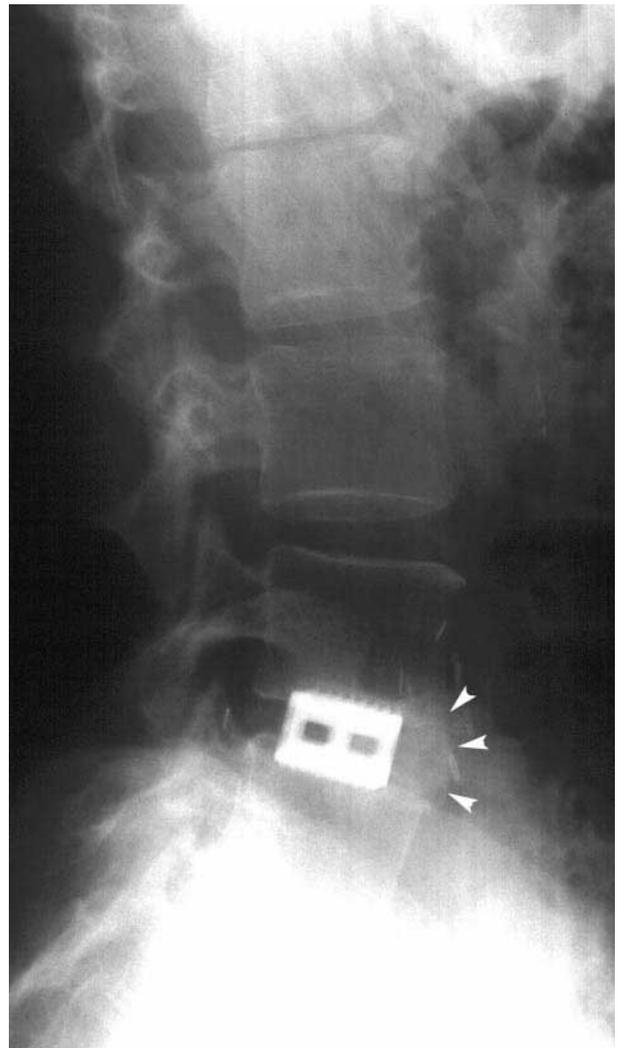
Lateral radiograph of a patient who has undergone L₄₋₅ interbody fusion from an anterior approach using titanium interbody cages and autologous bone graft. Two cylindrical implants can be seen side-by-side between the L₄ and L₅ vertebral bodies. A fusion mass of autologous bone graft extends between the anterior extent of the L₄ and L₅ vertebral bodies (arrowheads).
